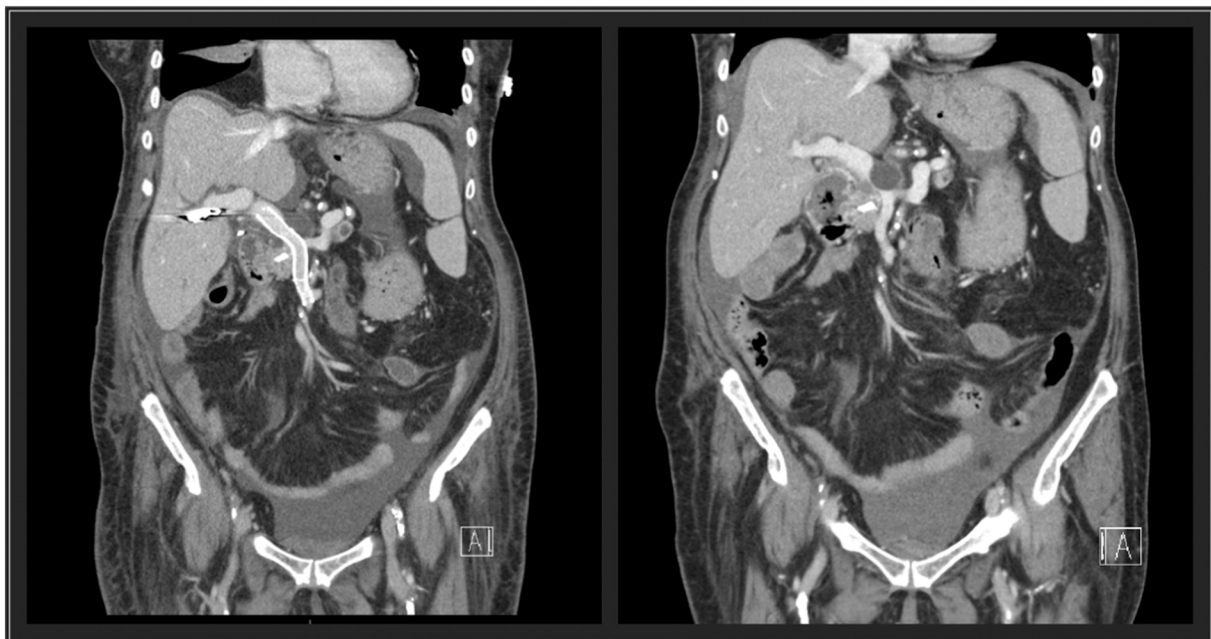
CT mesenteric angiogram both before and after stenting. The image on the left shows successful recanalisation of the portal vein and a return of portal blood flow while the image on the right shows a lesion compressing the portal vein with duodenal varices.
